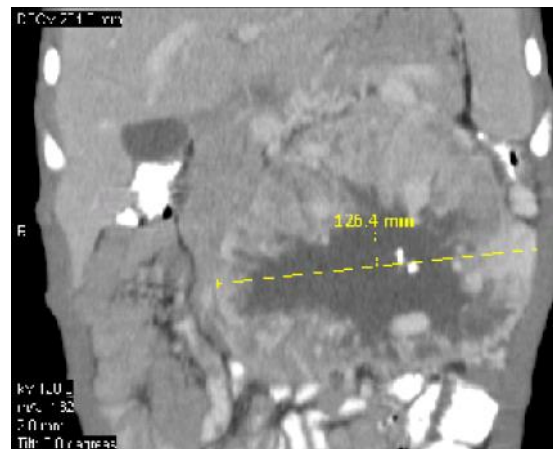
Neuroblastoma: CT image showing large retroperitoneal mass with focal calcification at the centre.
